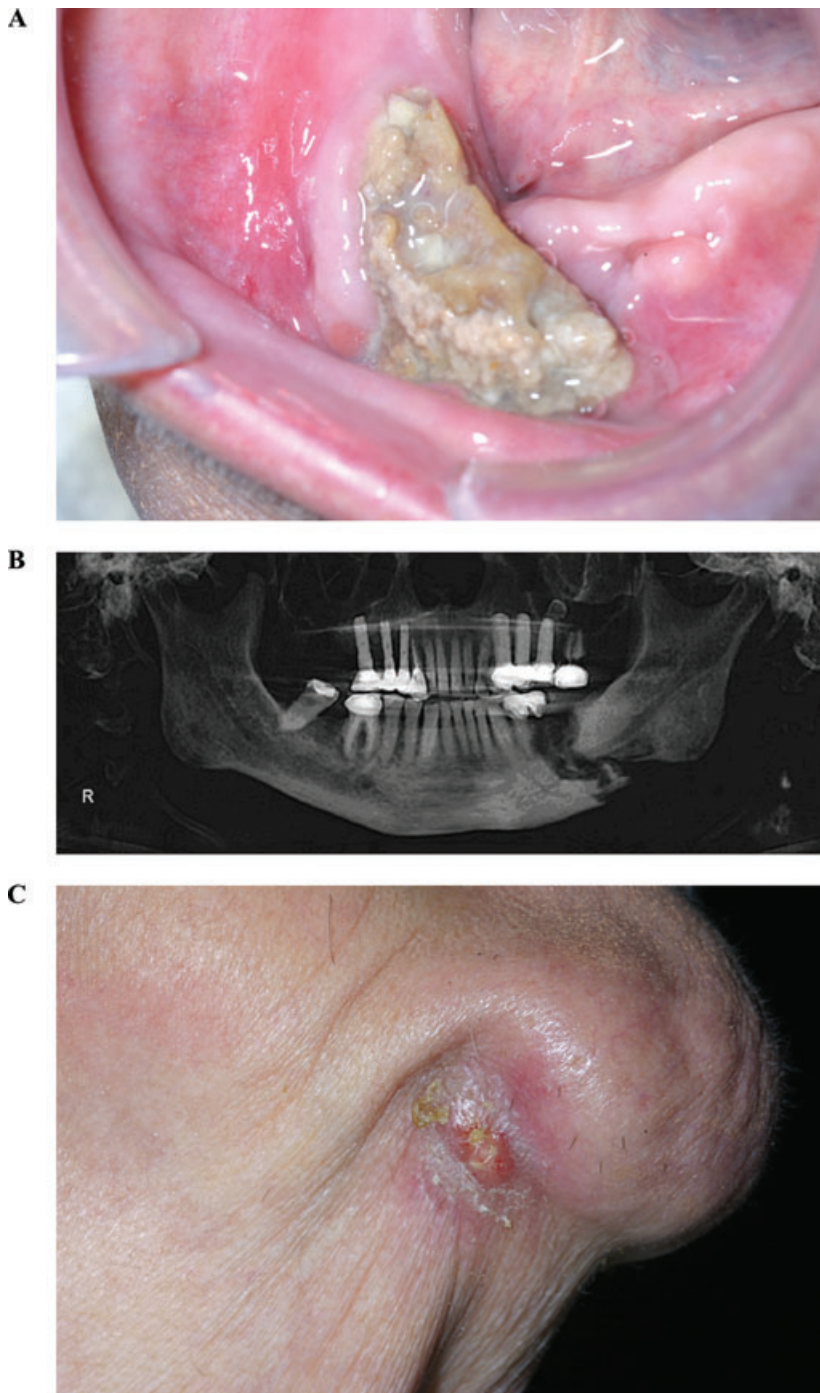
(A) Large segment of necrotic right mandible in a patient with end-stage breast cancer and a history of zoledronate exposure (Stage 3 BRONJ). (B) Panoramic radiograph of the mandible demonstrating a pathologic fracture and a large region of osteolysis. (C) Draining extraoral fistula in the region of the right mandible where the displaced bone has protruded through the skin.
